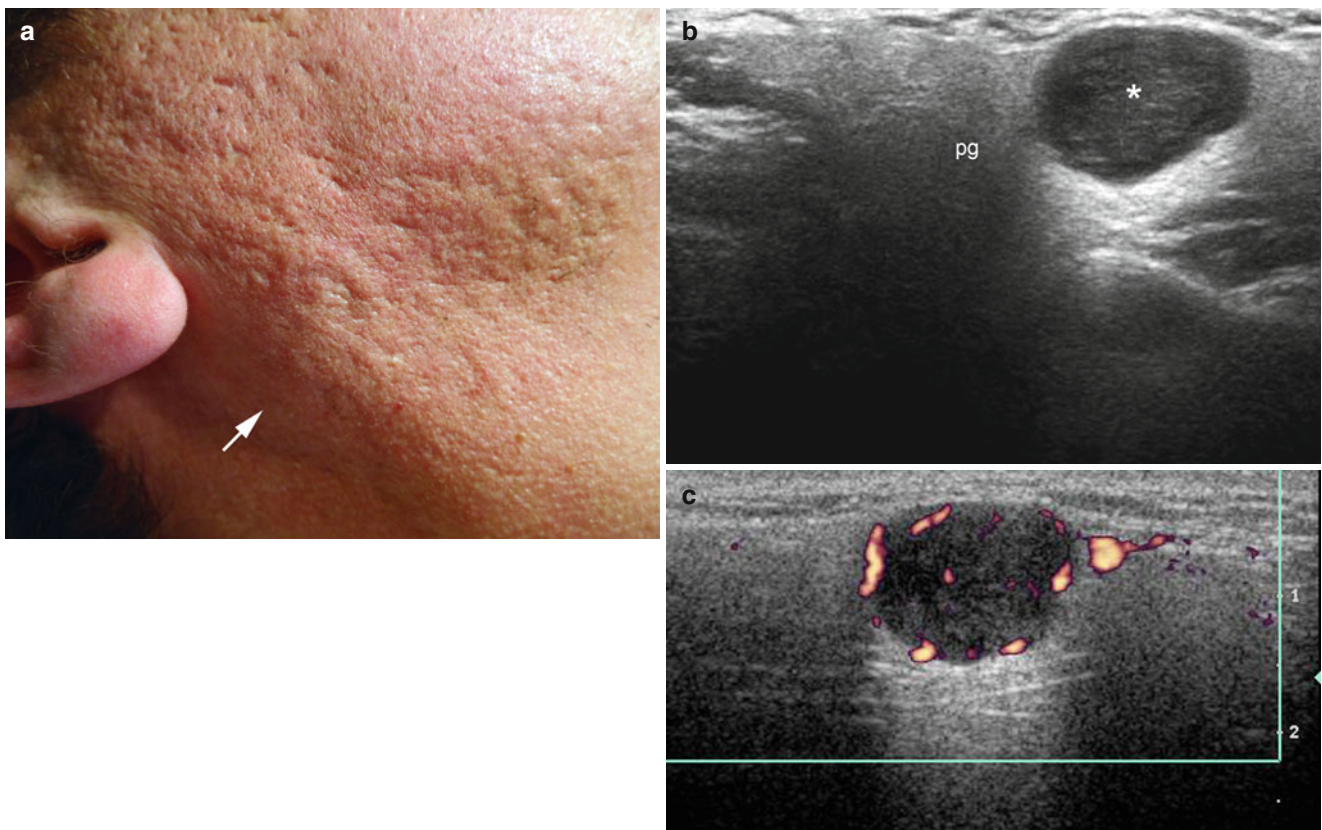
(a–c) Pleomorphic adenoma. (a) Clinical image of a patient that presented with a palpable lump (arrow) in the right infra-auricular region. The patient also had several atrophic acne scars. (b) Grey scale ultrasound image (transverse view) shows a well-defined oval-shaped
